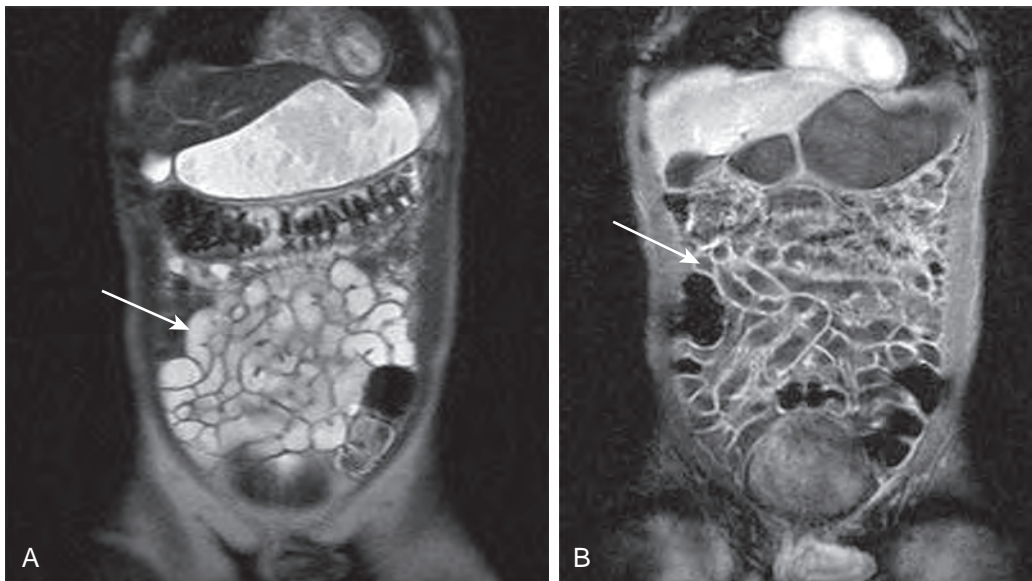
Oral contrast material. Coronal single-shot turbo spin-echo (SSTSE) (A) and gadolinium-enhanced 3D MR images (B) were obtained following oral administration of 1.5 L of Metamucil mixed with water. The water-soluble intraluminal contrast material demonstrates high signal intensity on the T2-weighted SSTSE images (arrow in A) and low signal intensity on the T1-weighted, 3D gradient-echo images (arrow in B).
